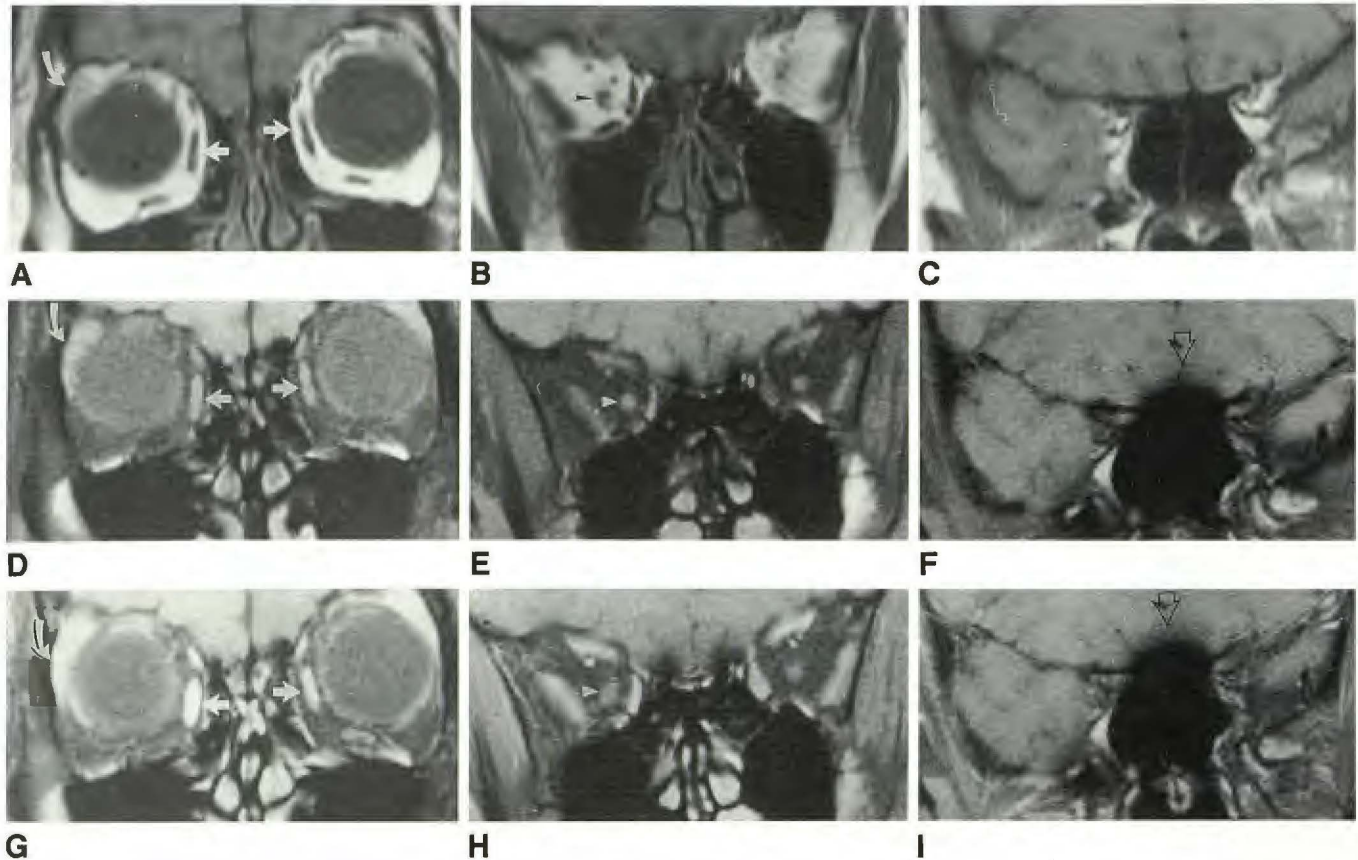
Normal volunteer. Coronal T1-weighted images (600/20/2) (A–C), coronal T1-weighted images with fat suppression (D–F), and postcontrast coronal T1-weighted images with fat suppression (G–I). Margins and outlines of extraocular muscles (straight white arrows), optic nerves (arrowheads), and lacrimal glands (curved arrows) are much better defined on fat-suppression images. Extraocular muscles enhance intensely and they appear slightly larger than on conventional T1-weighted images. Also, there is increased magnetic susceptibility artifact at ethmoid air cells and subfrontal regions on the fat-suppression images (open black arrows); however, the orbits are not affected significantly.
